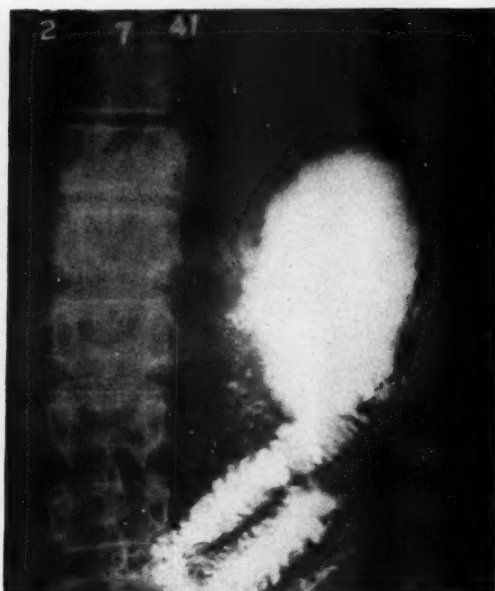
Roentgenogram, Feb. 7, 1941, showing remaining portion of stomach with satisfactory function of the gastro-enterostomy, approximately 14 months after operation.
